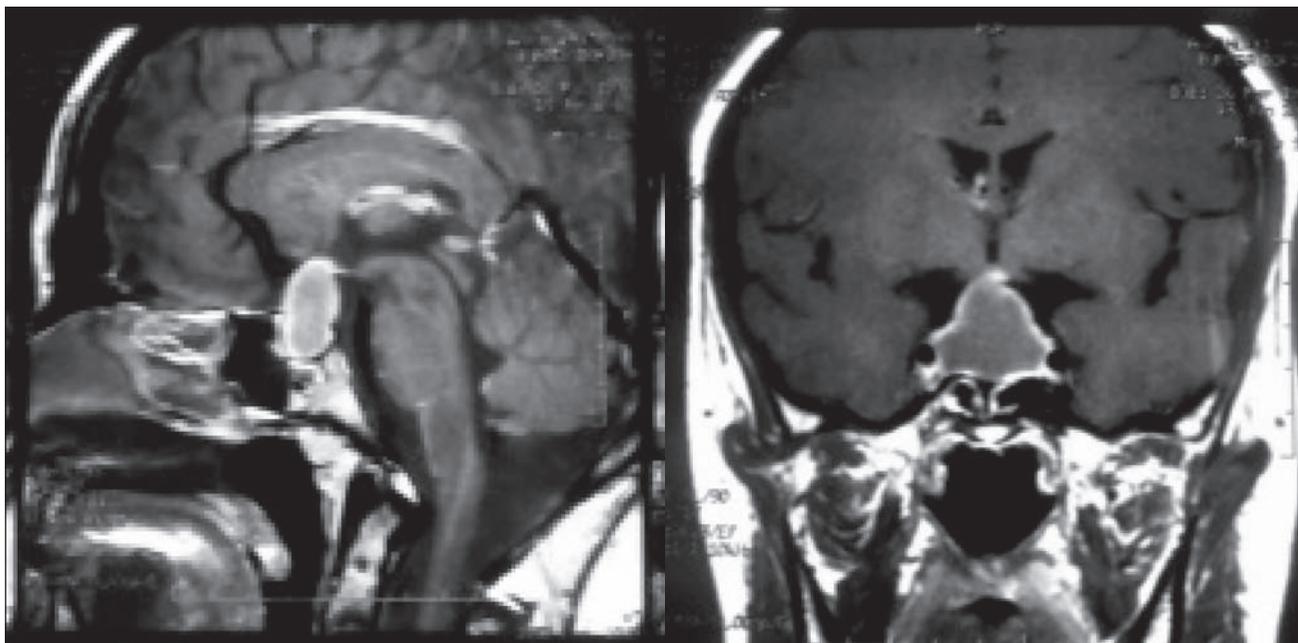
Cerebral MRI: sellar-suprasellar mass that was centrally isointense with peripheral hyperintensity on T1 -weighted images and was iso-hyperintense with peripheral hyperintensity on T2-weighted images. After the administration of gadolinium, rim enhancement was seen
